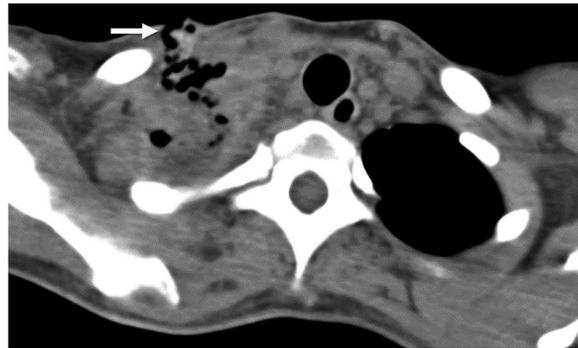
Infection in a patient with fever and clinically evident supraclavicular infection 1 month after right thoracic outlet decompression. (a) Chest radiograph shows a confluent right upper lobe airspace opacity with some mottled gas at the right apex. (b, c) CT images with lung (b) and soft-tissue (c) windows show pneumonia as well as an open tract from the pulmonary infection through the pleura and to the skin (arrow in c). Patients who have undergone thoracic outlet decompression are at risk for pleural space and lung infections due to communication with surgical bed infections via violations of the apical pleura.
